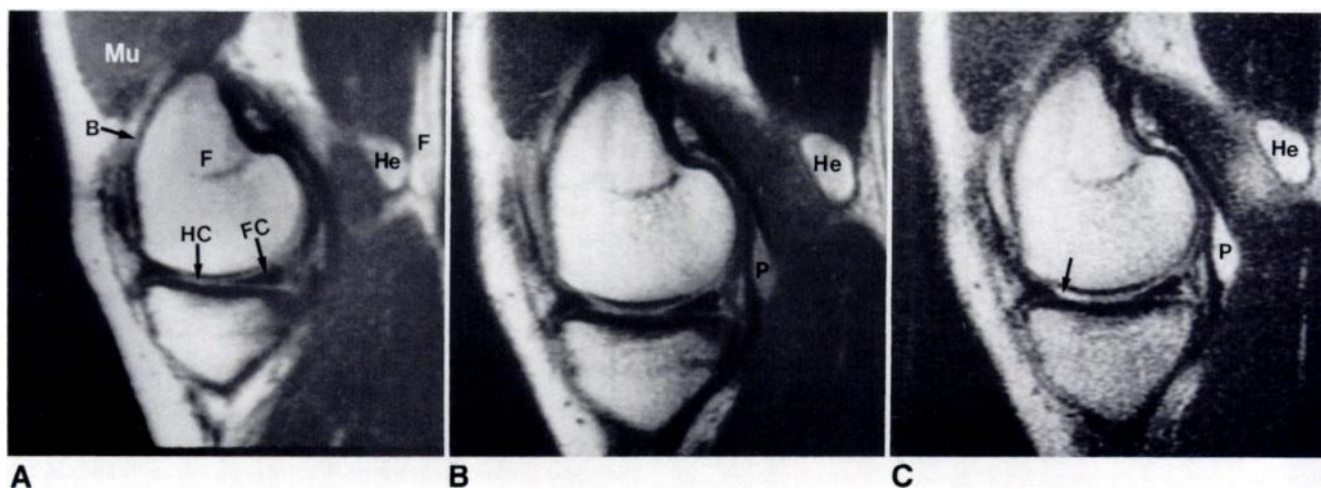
Sagittal MR images (1.5-T Signa; General Electric, Milwaukee) of a posttraumatic knee show different signal characteristics of cortical bone, fibrocartilage, muscle, fat, hyaline cartilage, hematoma, and proteinaceous fluid.
